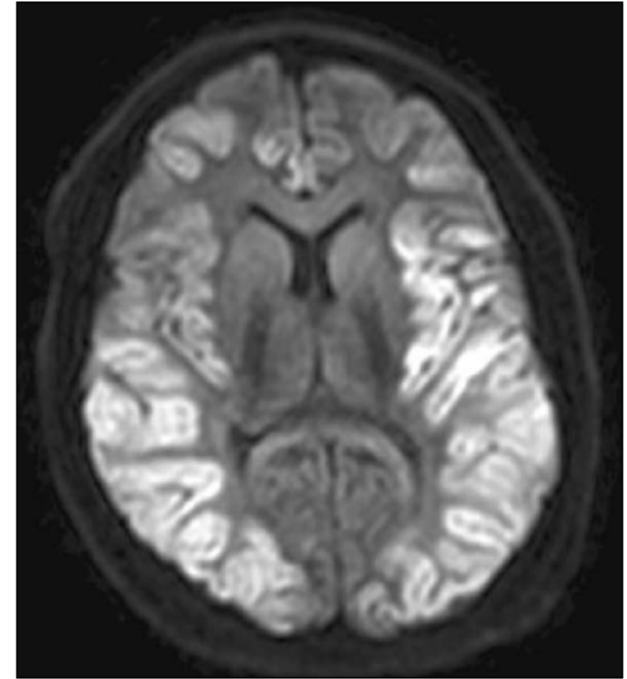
MRI of the brain (diffusion-weighted image)
